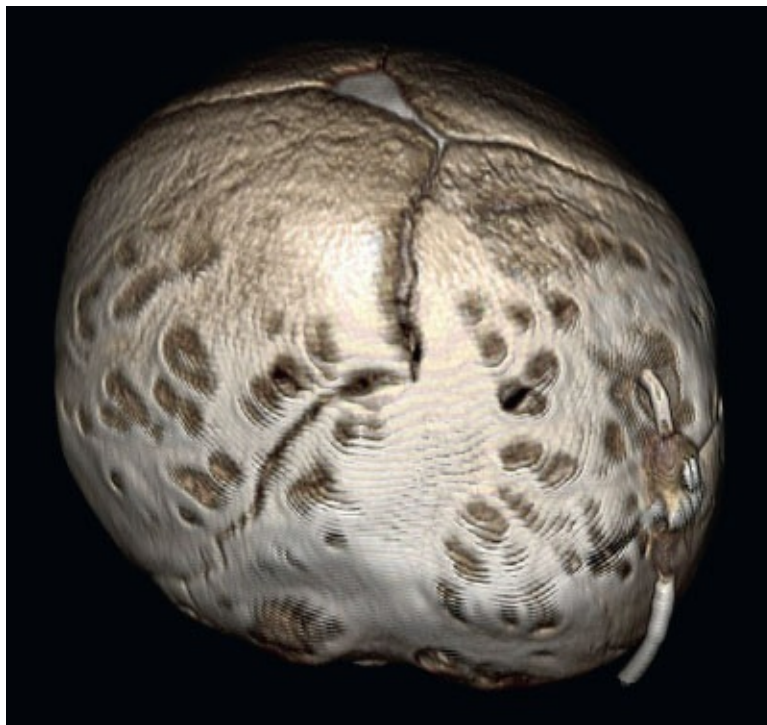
• Posterior coronal view of 3D CT scan of infant with right unilateral lambdoid craniosynostosis, who
